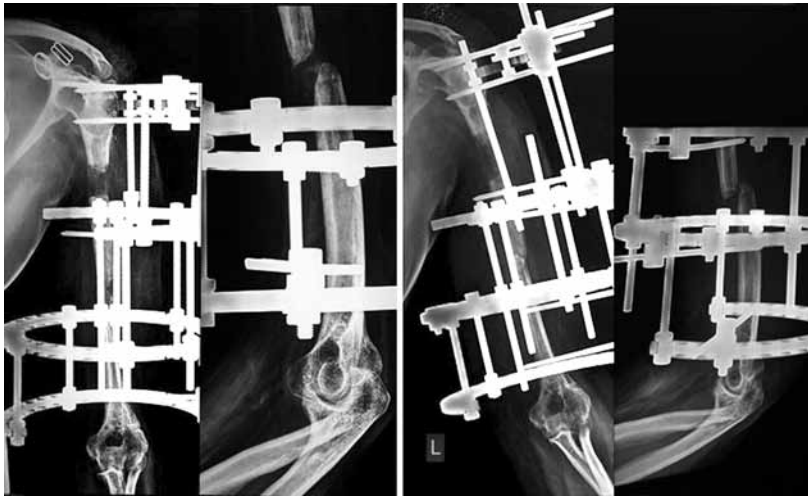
(g, h): Plain radiograph of left humerus of the same patient, even there is some overlap of the fragments at the compression site
